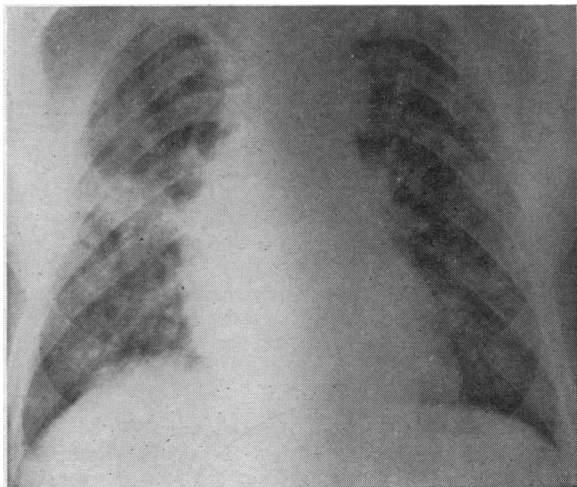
Case 1 (M.J.). Roentgenogram of chest (January 2, 1942), showing diffuse mottled infiltrations throughout both lungs and a density extending from the right lung root.
